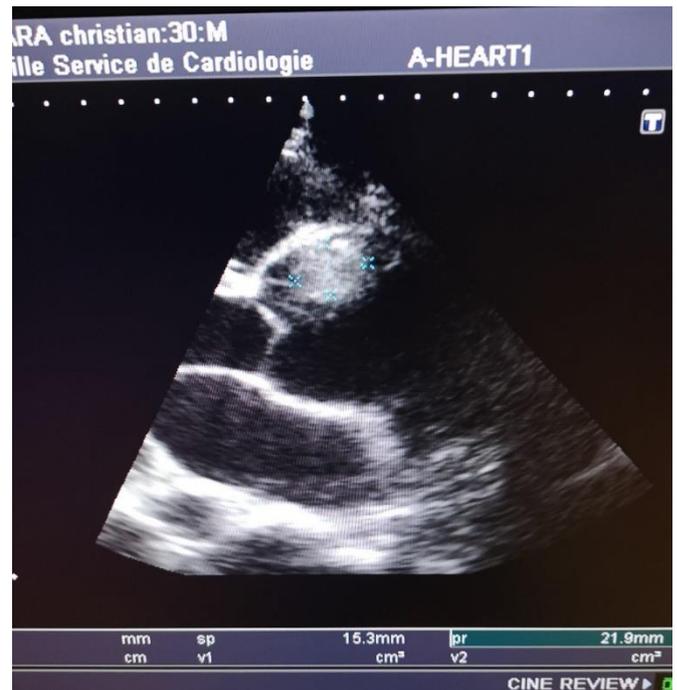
Echocardiography showing partial thrombosis in ascending aorta.
